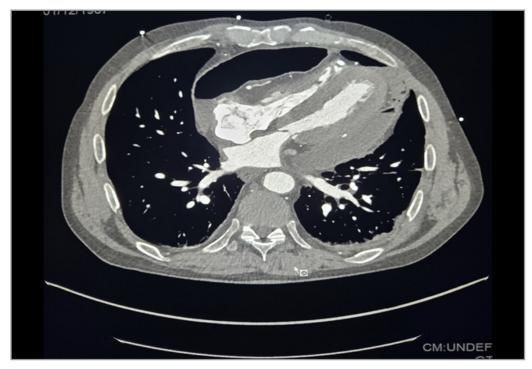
CT scan showing Pneumopericardium
